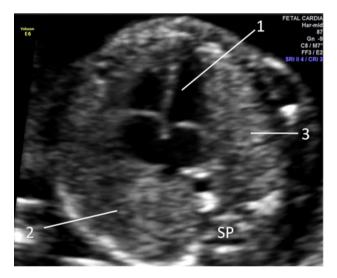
Transverse axial sonogram of thorax. (1) 4 chamber Heart (2) Right lung (3) Left lung
